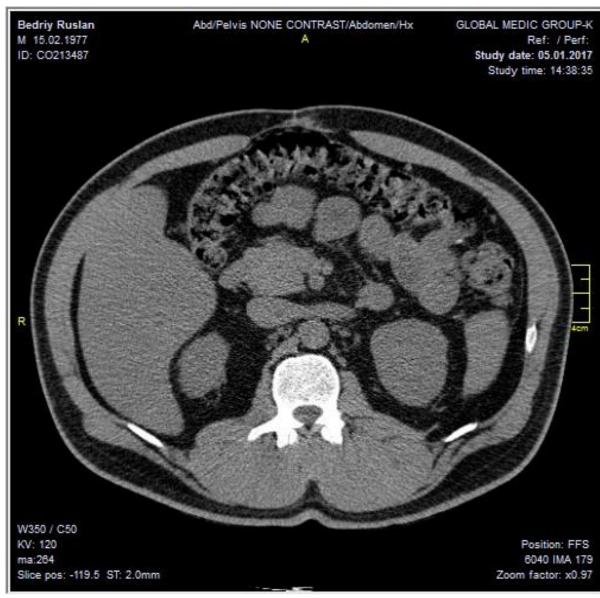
Spiral CT 5/1/17.
